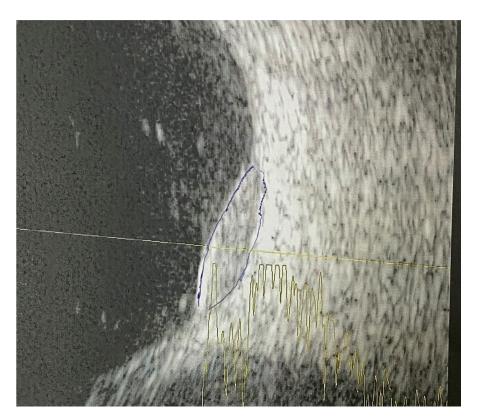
B-scan ultrasonography of the left eye showing choroidal mass with low to medium internal reflectivity.
